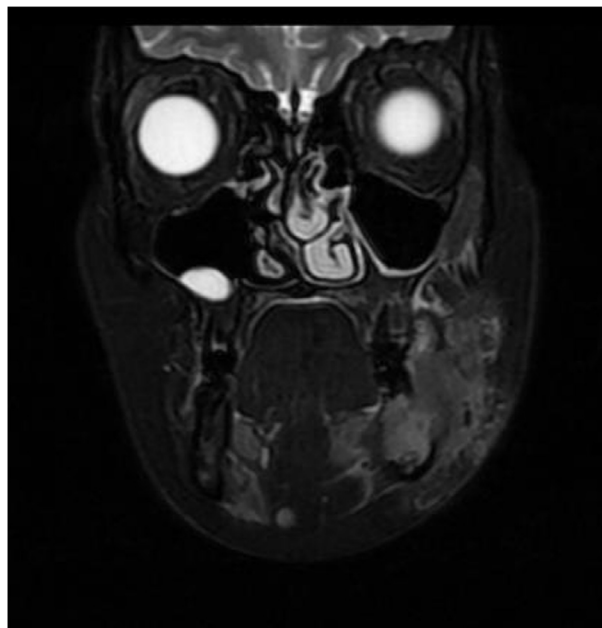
Coronal MRI (T2 weighted).
